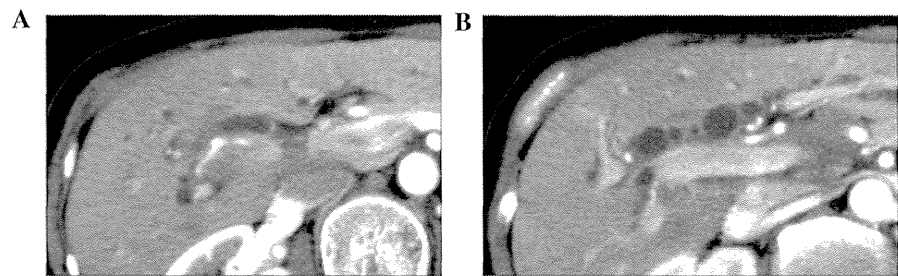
Computed tomography scans revealing (A) direct invasion of the right hepatic artery and (B) perineural invasion of the common hepatic and celiac arteries.
